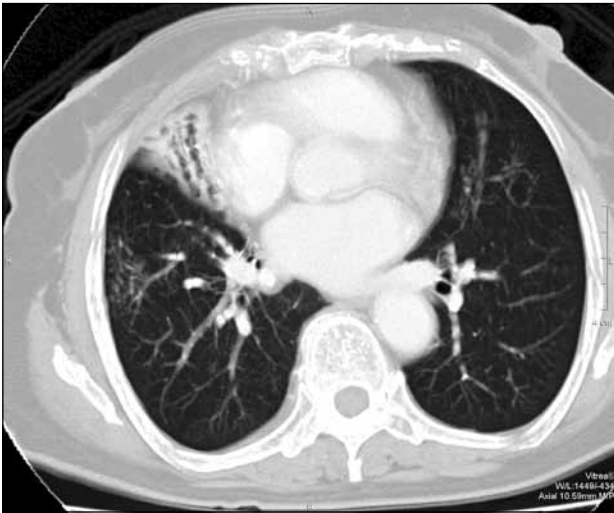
An adult male with confirmed non-tuberculous mycobacteria infection (*Mycobacterium chelonae*): an axial post-contrast computed tomographic scan of thorax in a lung window and maximal intensity projection showing tree-in-bud opacities in the right lower lobe, with consolidation in the right middle lobe.
